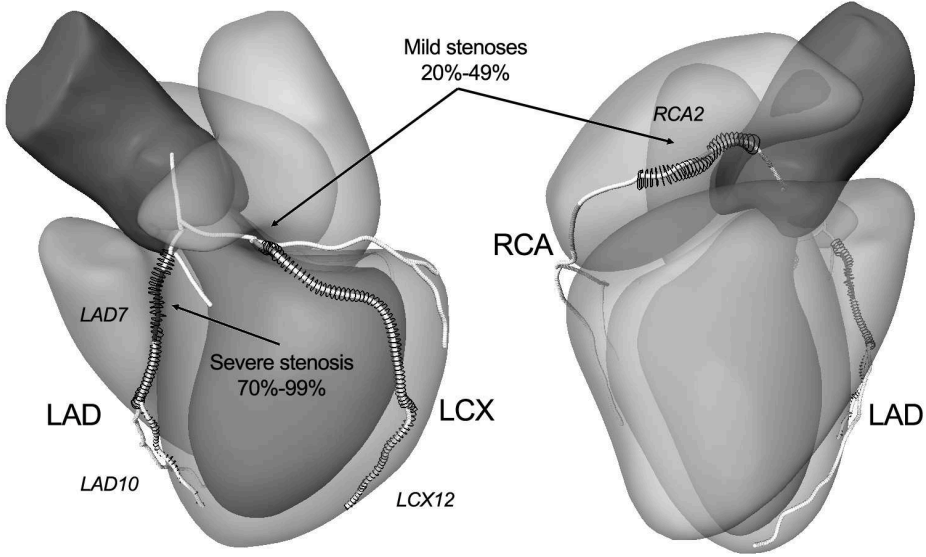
Example of CTA reference standard. Training dataset 08 presents five mild stenoses (one in RCA1, two in RCA2, one in RCA3, one in LCX12) and one severe stenosis (LAD7). Thus, segment LAD7 is selected to be segmented, as well as three other random segments in each of the main arteries, i.e. segments RCA2, LAD10 and LCX12.
